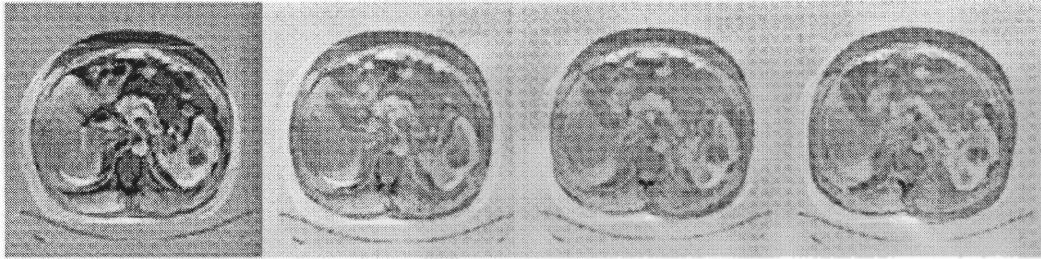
Four slices of the MR image volume encompassing the pancreatic region.
